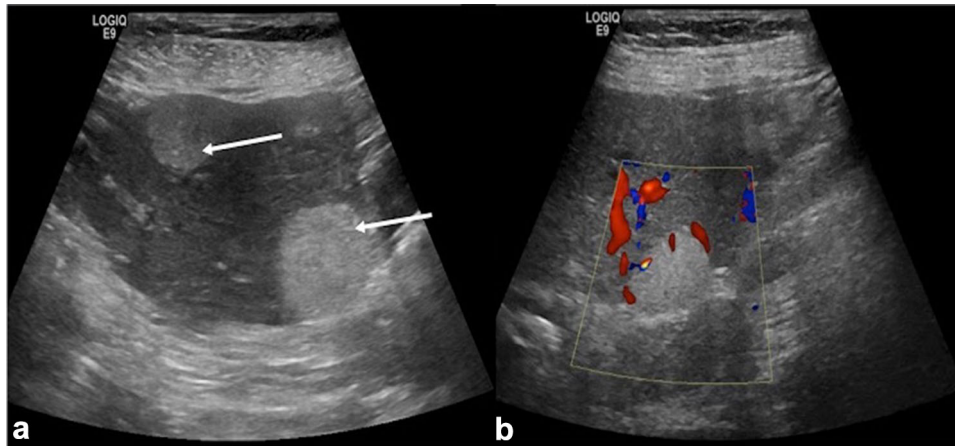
A 48-year-old woman taking oral contraceptives. a Grayscale ultrasound image demonstrates two hyperechoic liver lesions, both biopsy-proven hepatocellular adenomas. b Color Doppler image shows no internal flow within one of the lesions. The imaging
